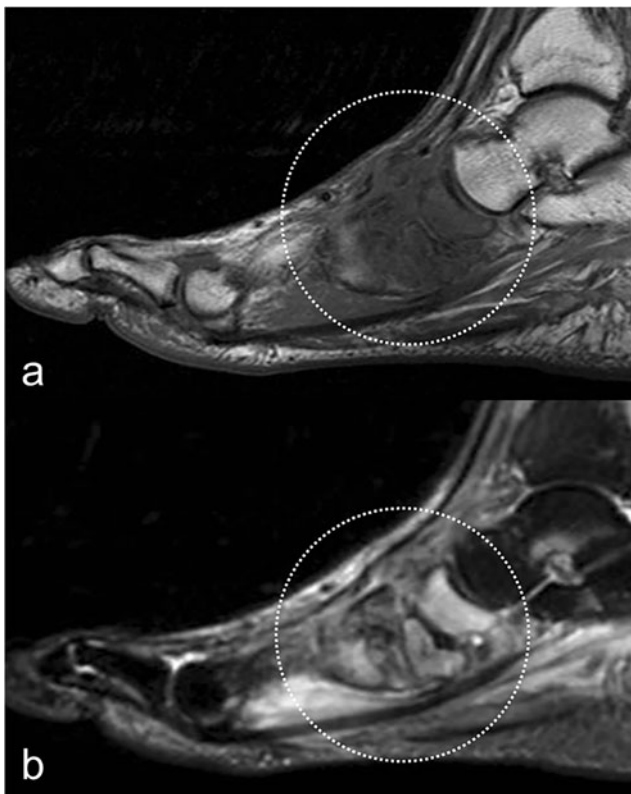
Neuroarthropathy with superimposed osteomyelitis. a Sagittal T1-weighted MR image shows fragmentation and subluxation at the midfoot (*circle*). The osseous structures of the midfoot appear to be absent, and an extensive, diffuse area of hypointensity is seen. b Sagittal T2-weighted, fat-suppressed MR image shows the osseous structures of the midfoot, which appear more regular and better defined than in a. This appearance, which is known as the “ghost sign,” is indicative of neuroarthropathy with superimposed osteomyelitis
